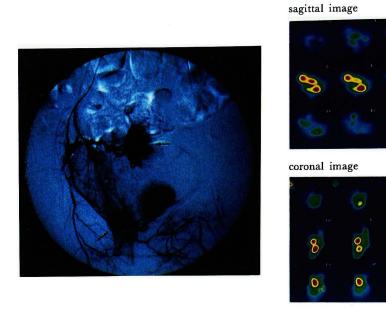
Patient 8: (A) DSA of the left hypogastric artery showed a hypervascularity in tumor lesions (arrow). (B) SPECT images (sagittal & coronal) revealed an intensive accumulation of ^{99m}TC-MAA in tumor-bearing sites (red area).
